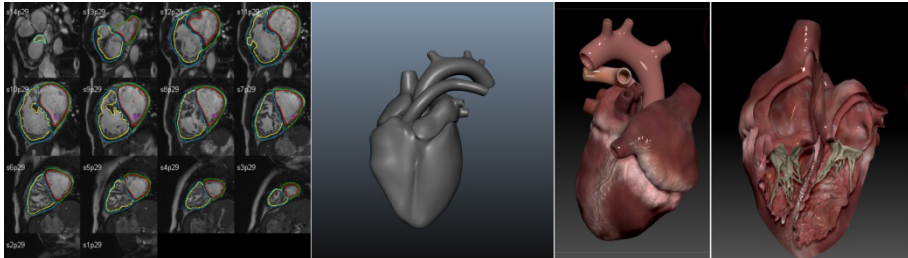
MRI with contouring data (left), reconstructed heart 3d model (center), heart 3d model with textures and internal structures (right).
